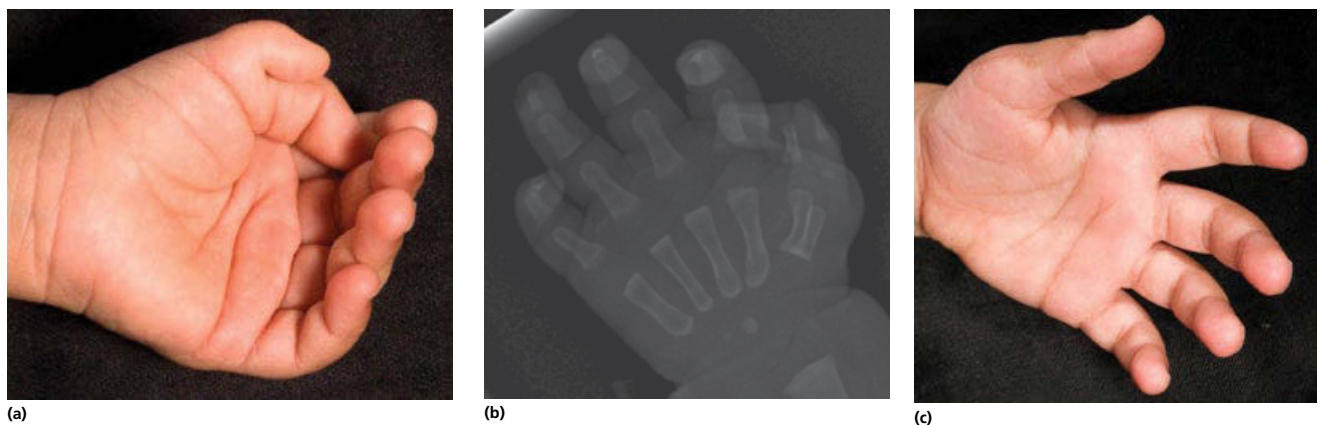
Reconstruction of a Wassel type VII duplication. (a) Preoperative image of an unbalanced type VII duplication. (b) Preoperative radiograph demonstrating smaller triphalangeal radial duplicate. (c) Postoperative image of corrected type VII duplication after removal of radial duplicate.
